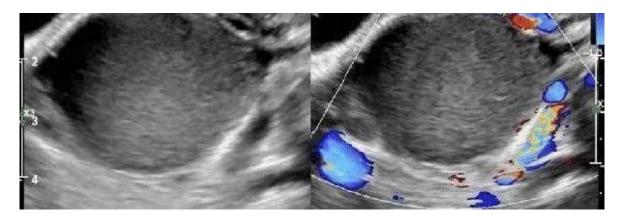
TVS image of Endometrioma showing ground glass appearance (Left), Figure 2: Doppler showing minimal peripheral vascularity (Right)
